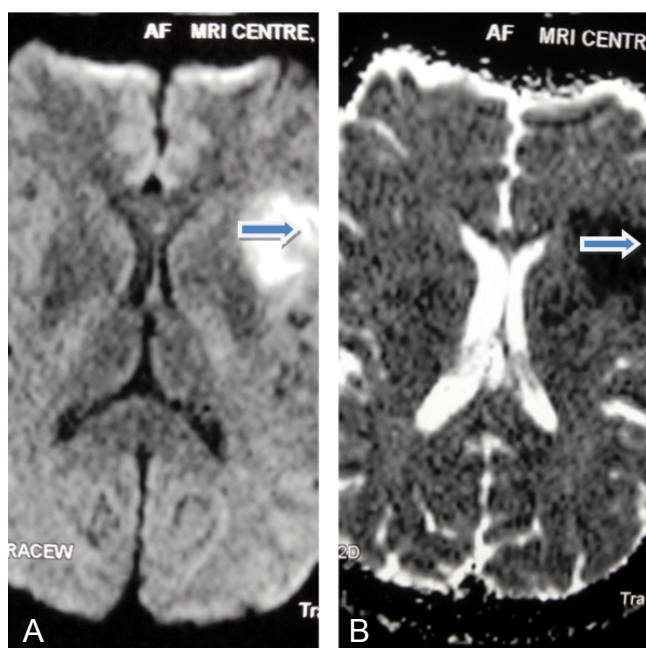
(A and B) Magnetic resonance imaging brain diffusion weighted imaging/apparent diffusion coefficient showing acute left perisylvian infarct
